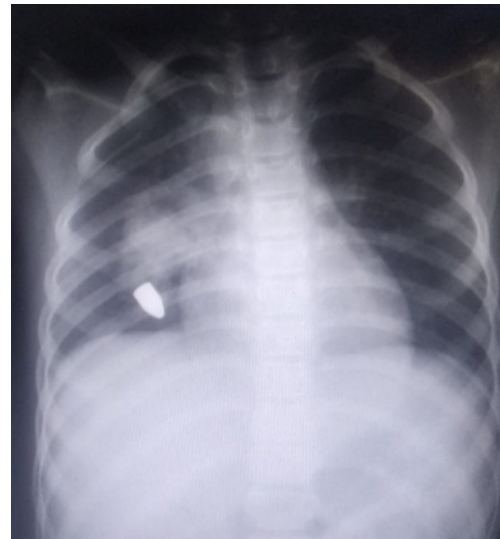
X-ray chest showing right sided pneumothorax.
